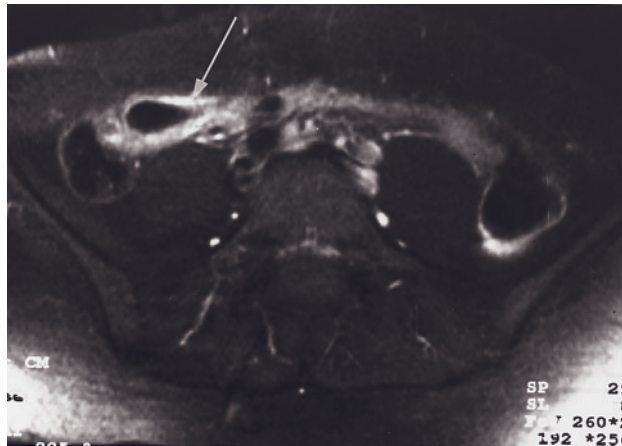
(Continued) postgadolinium fat-suppressed interstitial-phase 3D-GE (*f, g*) images demonstrate severe Crohn disease in another patient. The walls of terminal ileum (white arrows, *d-g*), cecum (open arrows, *d, f*), descending colon (black arrows, *d, f*), and sigmoid colon (black arrows, *e, g*) show thickening and edema (white arrows, *d, e*). Edema is seen as high signal in the wall. Associated mild mesenteric inflammation and fibrofatty proliferation are detected. The wall of terminal ileum shows trilaminar enhancement (white arrow, *g*) pattern due to the presence of submucosal edema, which is seen as low signal intensity. The walls of the cecum and colon show diffuse enhancement (open and black arrows, *f, g*). Coronal T1-weighted postgadolinium interstitial phase fat-suppressed 3D-GE image (*b*) in another patient with severe Crohn disease demonstrates multiple enlarged and enhancing mesenteric lymph nodes (arrow, *b*). Note that the walls ileal and colonic segments show diffuse and mucosal increased enhancement, respectively.
